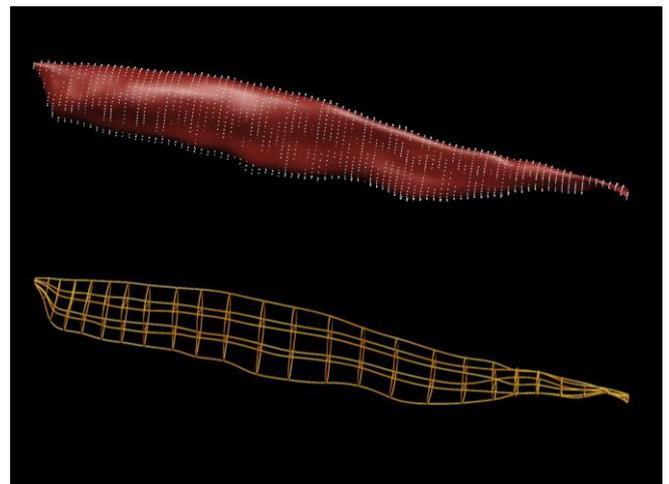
Data points segment for FCU from MRI images, and used to construct a 3D FE model.
